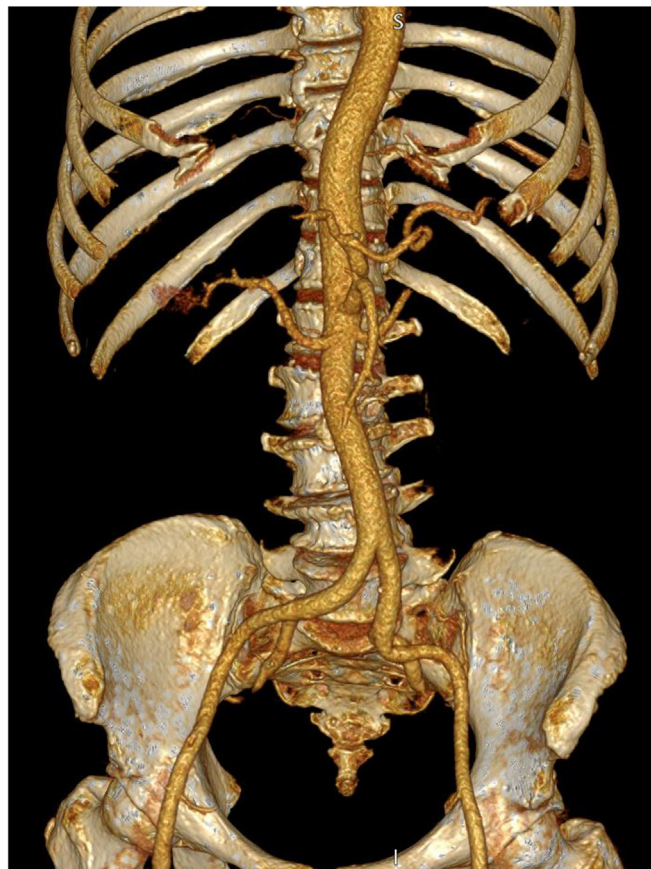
Postoperative three-dimensional computed tomography (CT) reconstruction.
